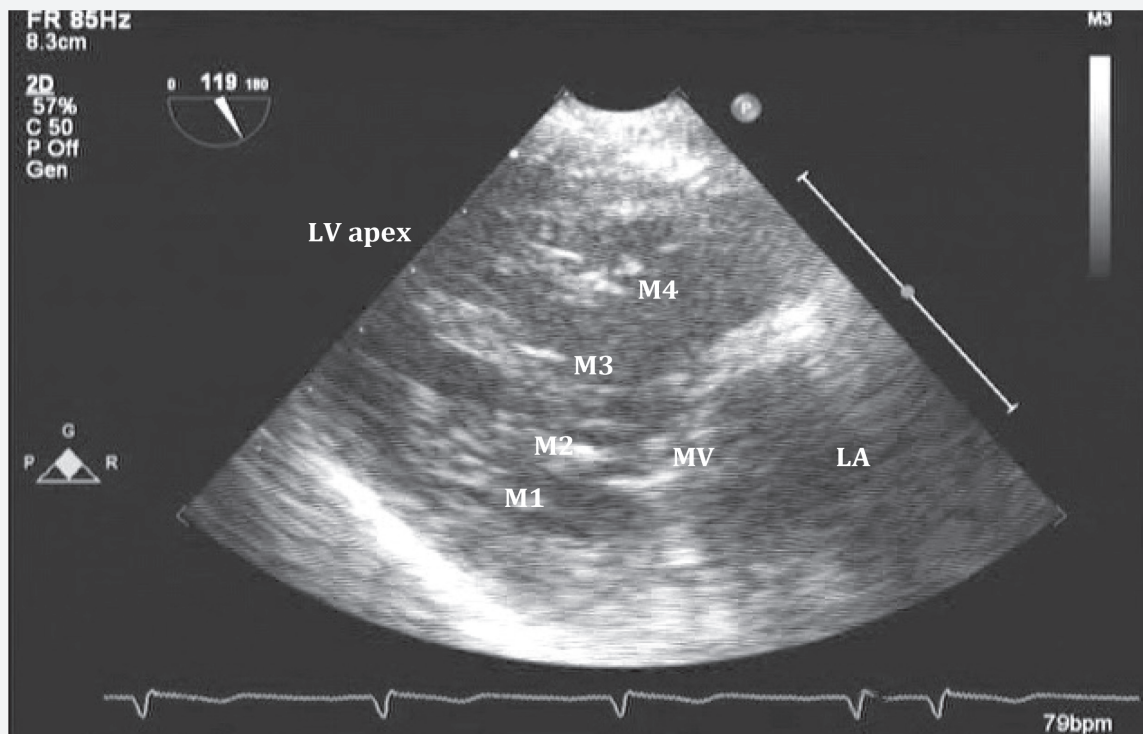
Transesophageal 2D echocardiography deep transgastric long-axis view of the mitral valve demonstrating chordal attachments to multiple papillary muscles (M1–M4). Abbreviations: 2D, two-dimensional; LA, left atrium; LV, left ventricle; MV, mitral valve.
